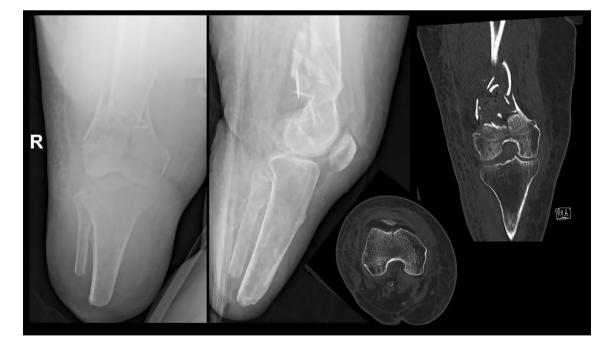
The right knee and femur radiographs with representative CT scan images showing a comminuted distal femur fracture with simple intraarticular extension in the setting of a prior BKA
